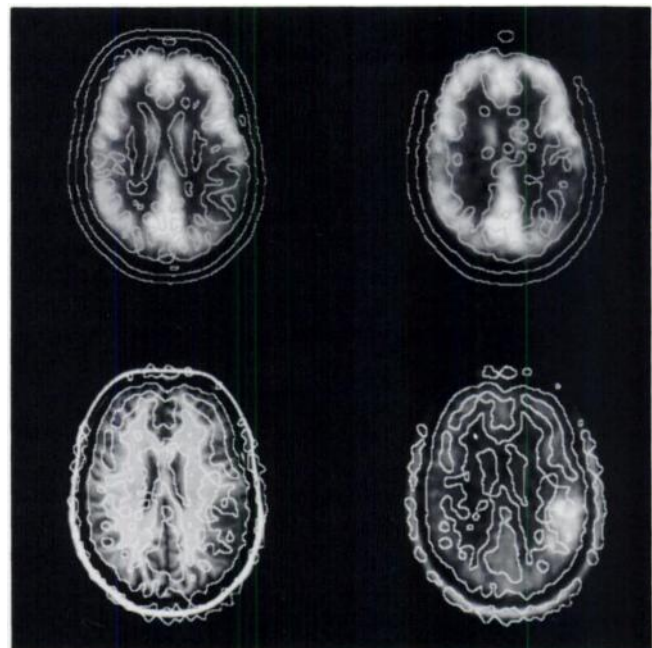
Coregistration of methionine-PET and MRI with a FDG-PET study, which served as reference. Despite the relatively different tracer uptake in the methionine-PET study, sufficient outlines in either study are presented to the user to visually inspect and control the registration process. Contours are exchanged between the FDG and MRI studies and FDG and methionine respectively. Top left: FDG-PET with contours from MRI. Top right: FDG-PET with contours from methionine-PET. Bottom left and right: contours from FDG-PET superimposed onto MRI and methionine-PET, respectively.
